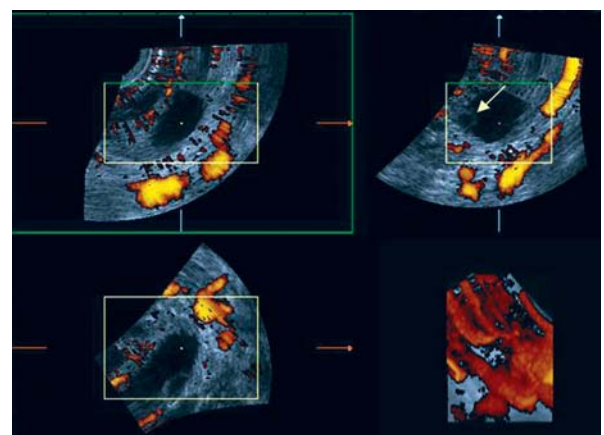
Small cystic lesions throwing up a surprise on 3D power Doppler. The 3D rendering shows a bizarre branching pattern suggesting malignancy which was confirmed after surgery
